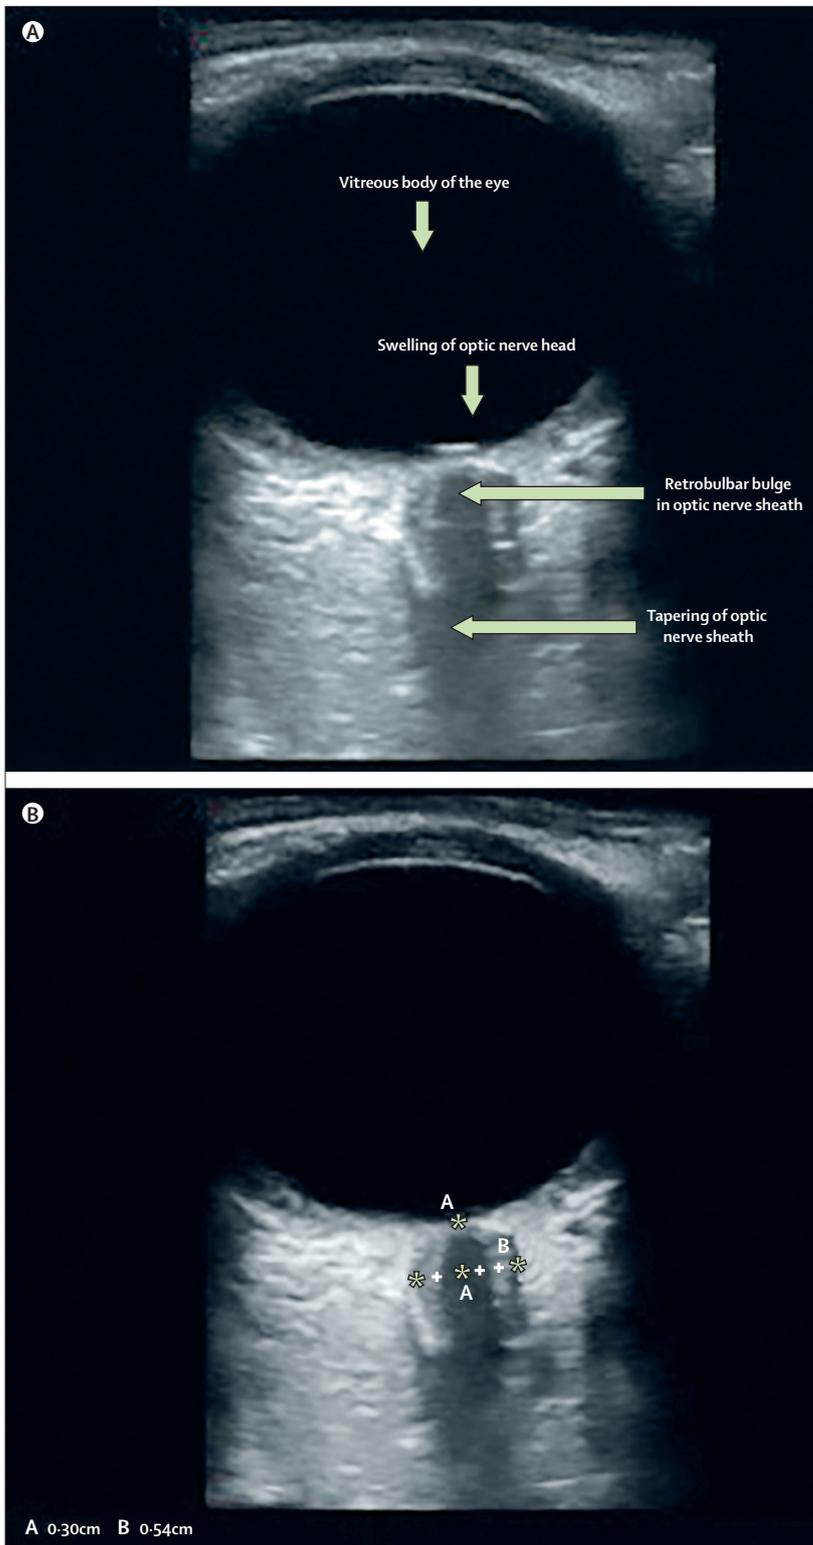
Use of optic nerve sheath diameter ultrasound in critically ill patients with tuberculous meningitis
